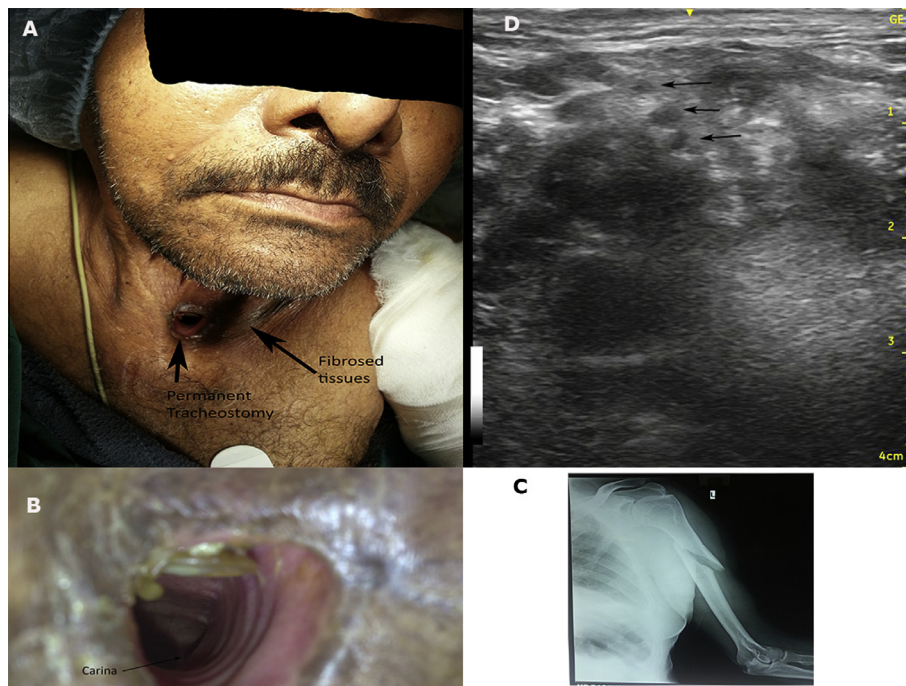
(A) Patient with permanent tracheostomy and surrounding fibrosis, (B) voice prosthesis, tracheal rings and carina visualised, (C) X-ray showing fracture humerus and (D) pre-block scan; arrows showing Brachial plexus between the scalene muscles.
